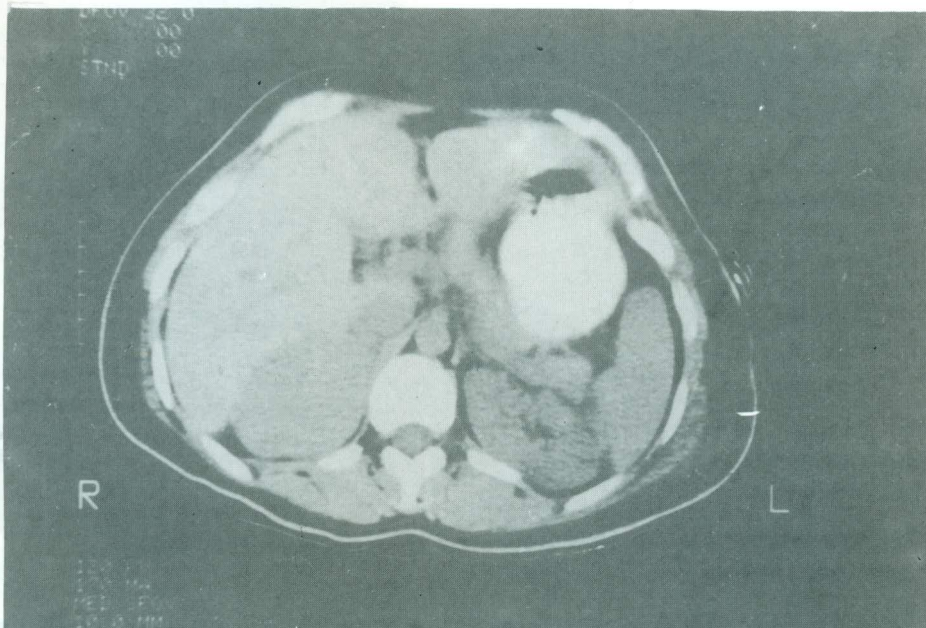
CT Scan of the abdomen, demonstrating a homogenous soft tissue mass involving the upper pole of the right kidney.
